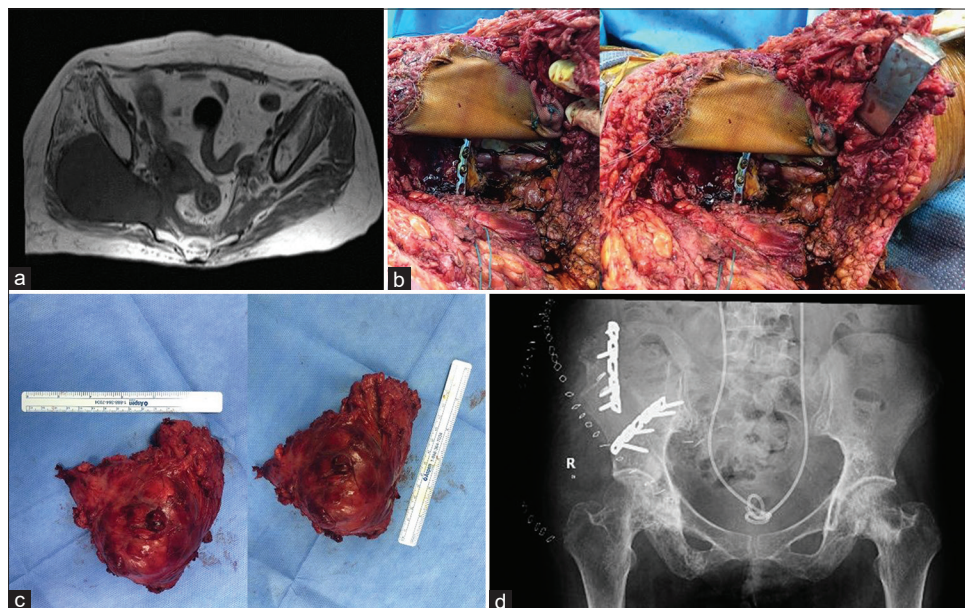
(a) Axial magnetic resonance imaging of the pelvis showed a lesion in the right sciatic notch extending to the gluteal area. (b) Utilitarian pelvic approach for SNDT after resecting the gluteal medius and minimus muscles; the arrow shows the Trevira attachment tube attached to the iliac crest and greater trochanter. (c) The resected tumor. (d) Postoperative anteroposterior pelvic radiograph shows surgical clips at the right gluteal region. Postfixation of the right iliac bone by plate and screws with bilateral double-J ureteral catheters
